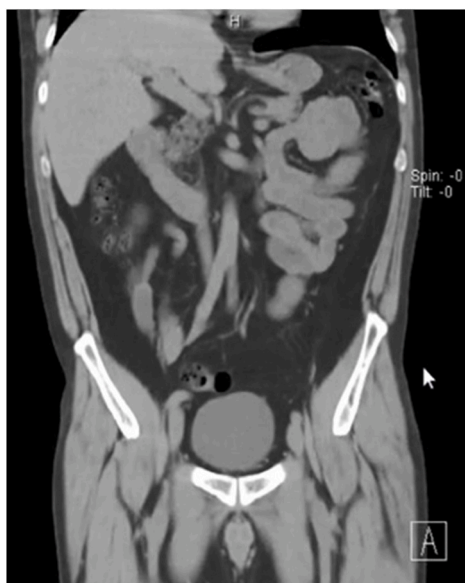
CT revealing dilated loops of small bowel.
